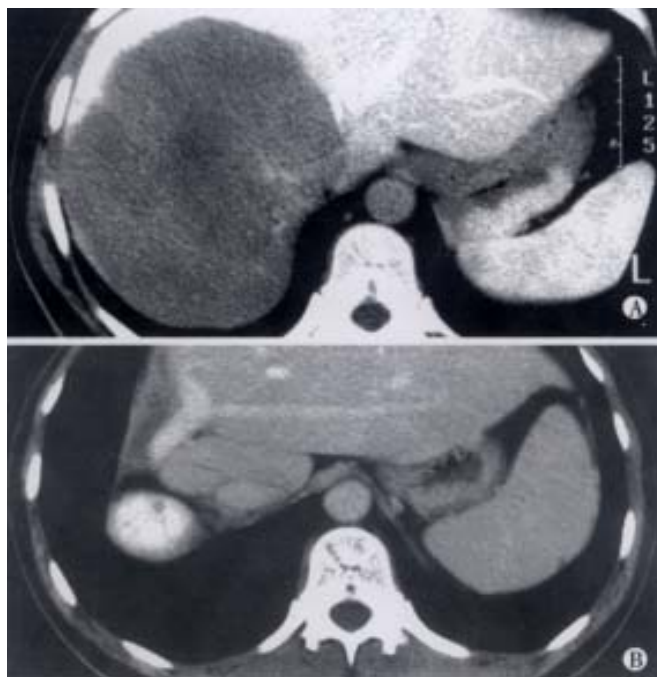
(a) Large solitary metastasis resected by extended right hepatectomy. (b) CT scan showing hypertrophied left and caudate lobes with no evidence of recurrence at one year.
